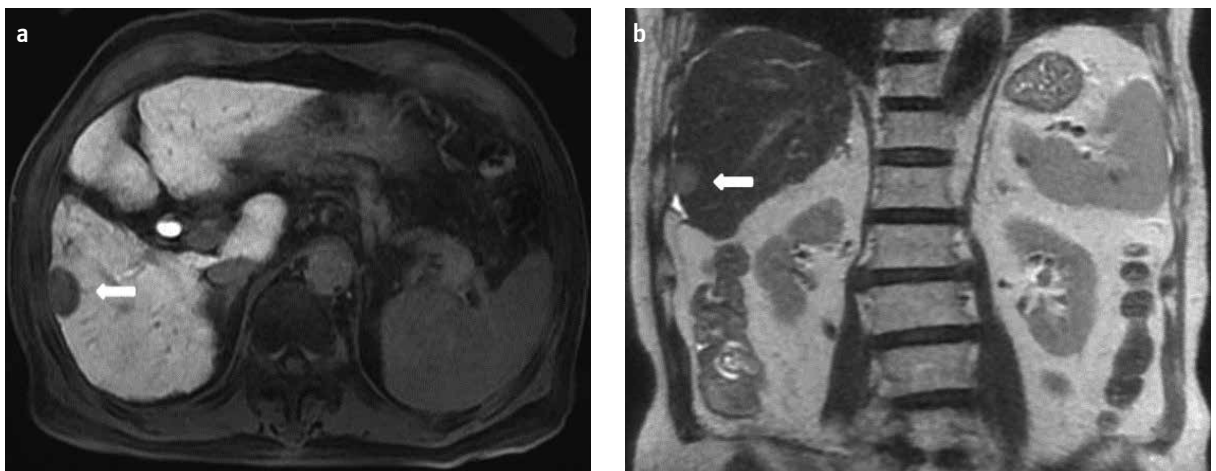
a, b. Axial (a) and coronal (b) MRI images show a subcapsular 2.5 cm tumor at segment 5 of the liver (arrow). The intestine is not shown around the liver capsule close to the tumor.
